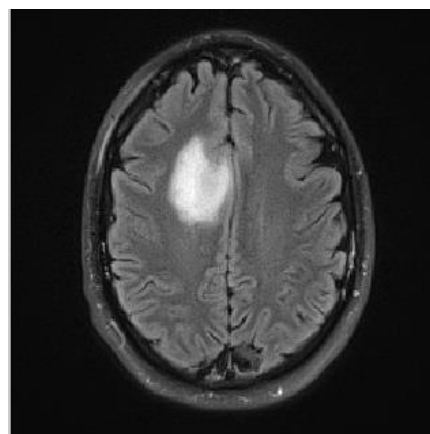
An example of Brain tumor MRI
